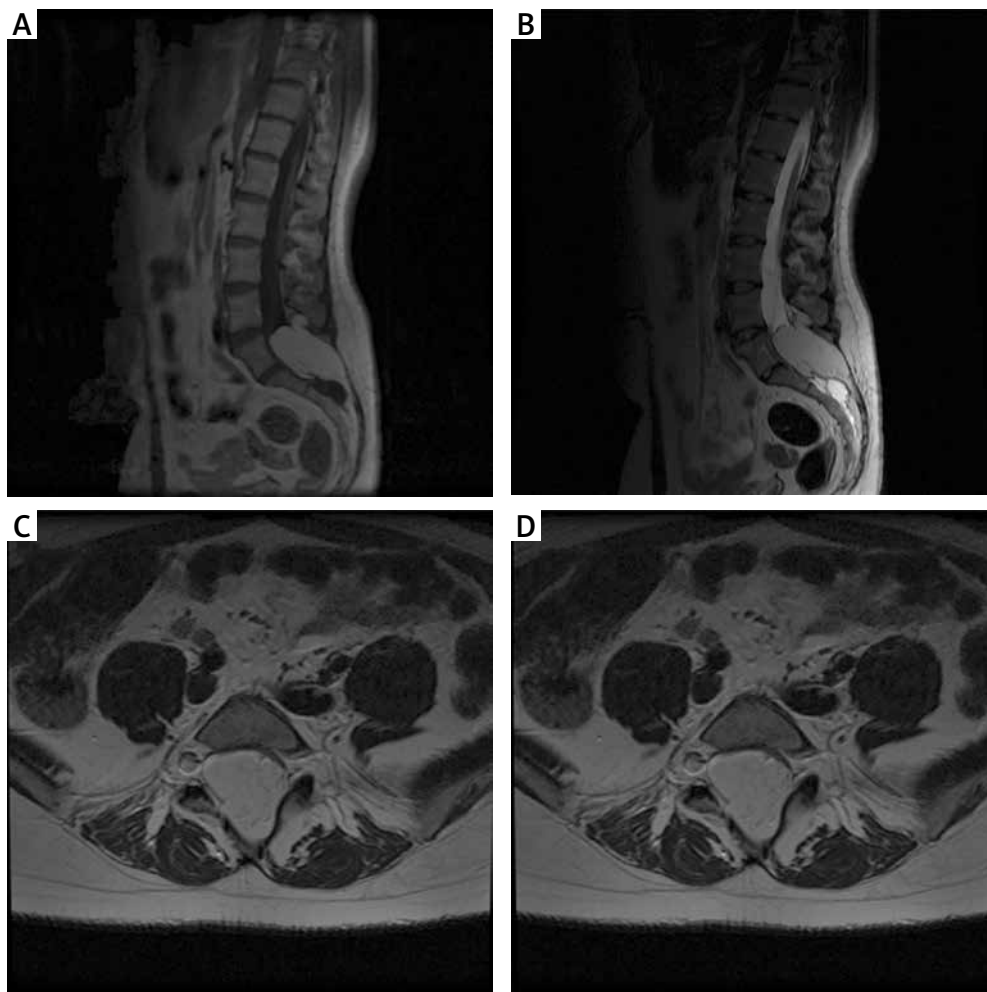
Pre-operative MRI examination of the first patient. A – T1 FSE S time with contrast; visible end-striatal fatoma and non-union of L5 and S1 arch. B – T2 time. C – axial sections at T2 time; widening of the spinal canal, filled with adipoma. D – axial sections at T1 time with contrast; the tumour shows no contrast enhancement
